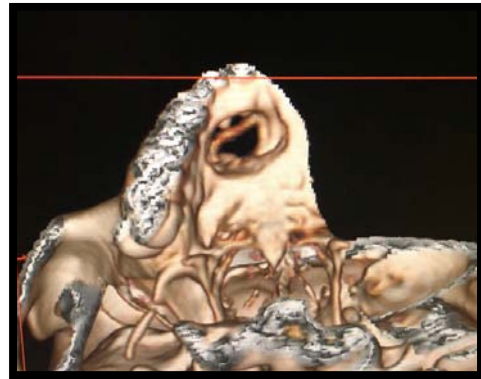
CT image showing palatal perforation
